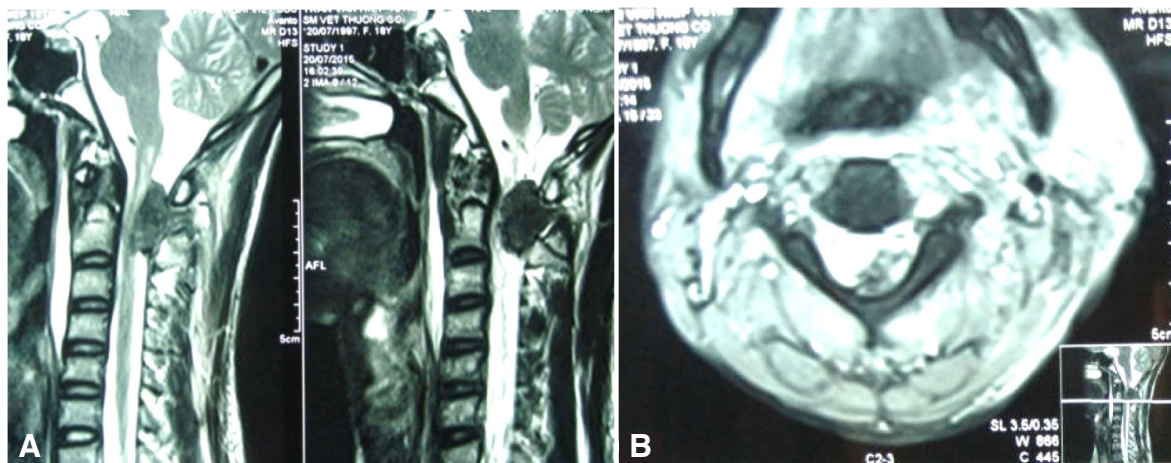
The second postoperative spinal MRI.
